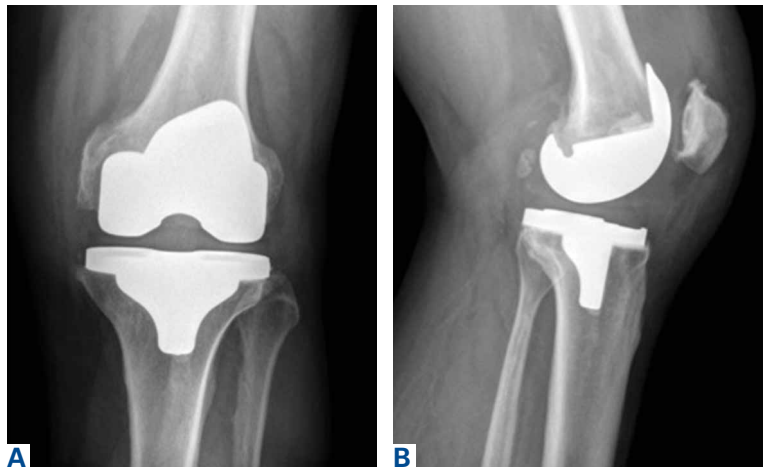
(A) Anteroposterior and (B) lateral radiographs of total knee prosthesis infected with *Plesiomonas shigelloides*.
